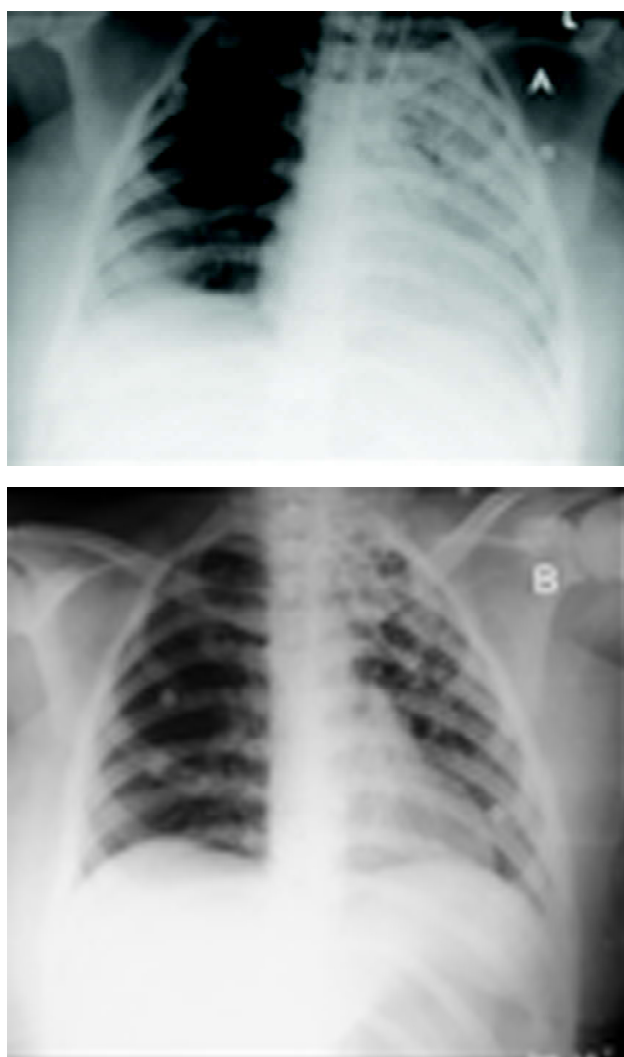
Chest X-ray on day 4. b: Chest X-ray on day 13. The progression of these X-rays shows significant improvement of the patient's initial respiratory condition.
